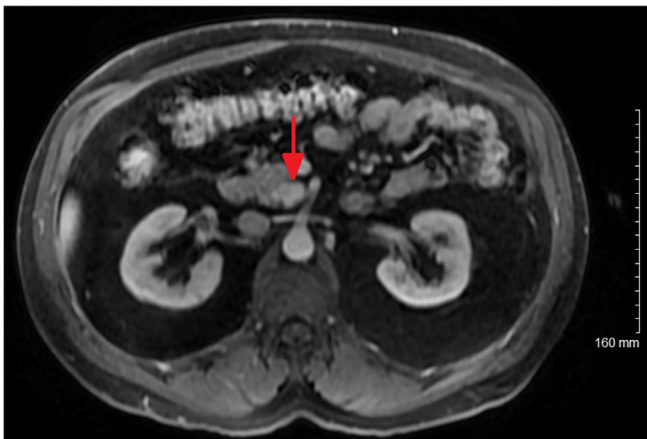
Magnetic resonance image of the aneurysm (arrow) within the pancreaticoduodenal artery (PDA).
